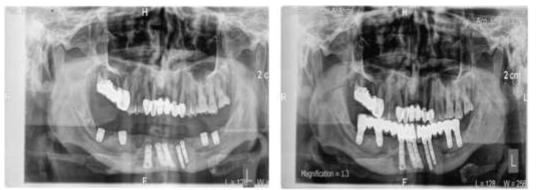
Immediate postoperative panoramic radiograph Figure 4: Three months postoperatively
